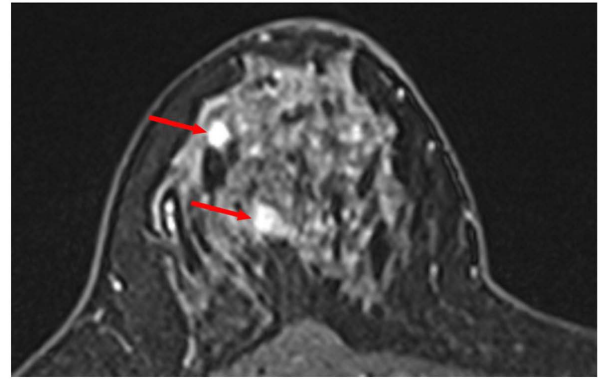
Magnetic resonance imaging revealed nodules (red arrows) in the right breast.
